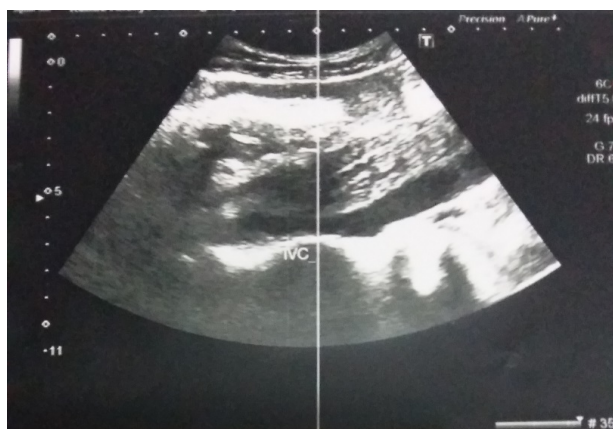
Ultrasonographic image of the patent Inferior vena cava
